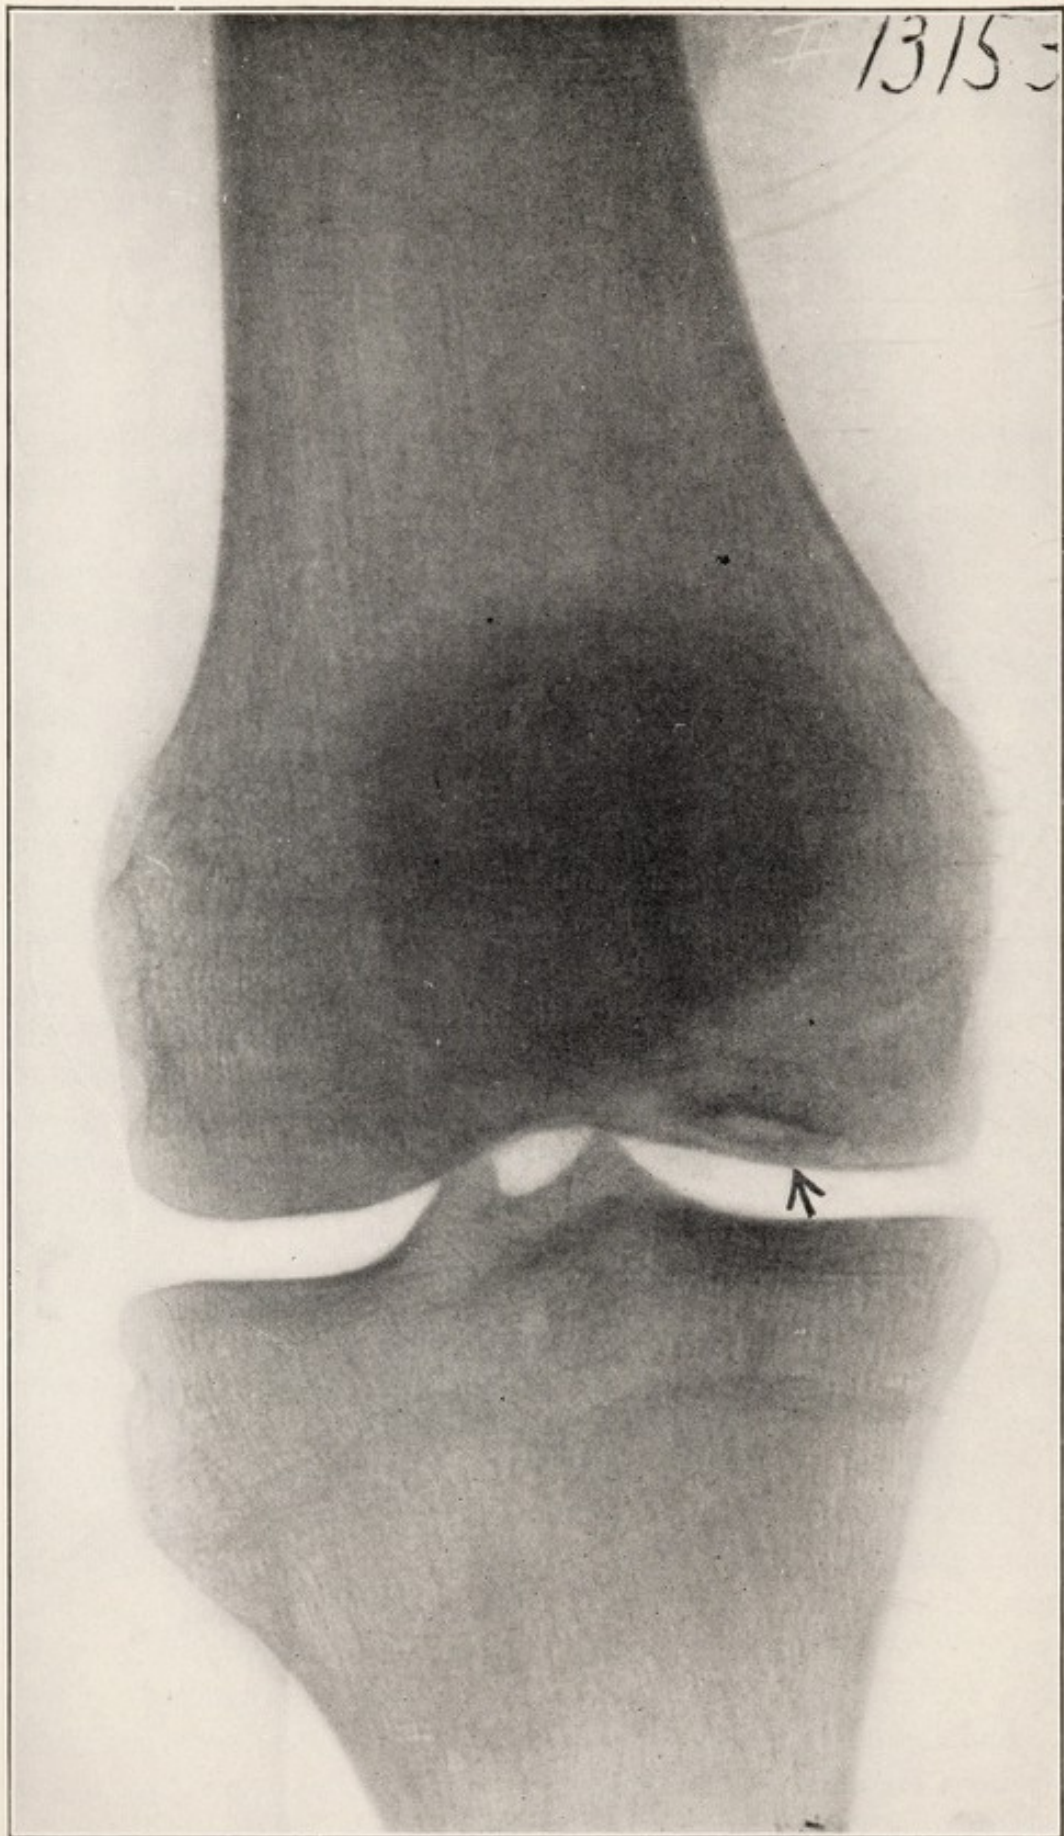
X-RAY OF OSTEOCHONDritis DISSECANS, SHOWING TRIANGULAR AREA OF RAREFACTION ON MEDIAL CONDYLE OF FEMUR SURROUNDING SMALL AREA OF INCREASED DENSITY; ARTICULAR CARTILAGE STILL INTACT.
